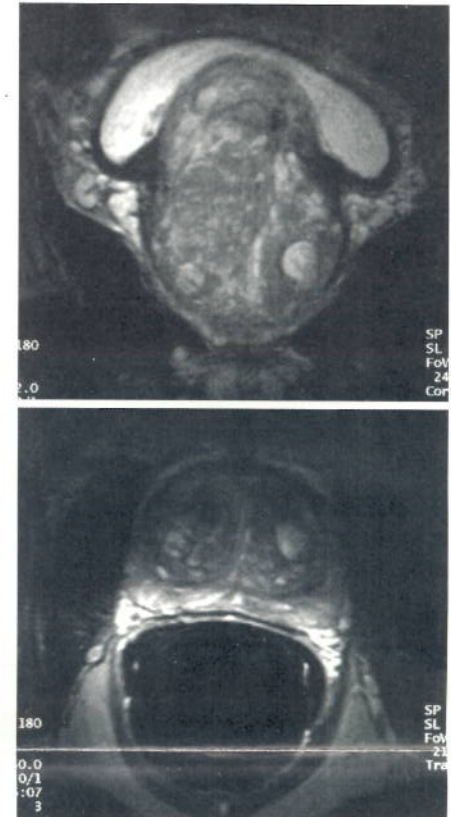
A. Coronal and B. axial Turbo Spin Echo T2-weighted (TR 7102, TE 112) endorectal coil images of patient with BPH. The brighter peripheral zone is compressed by BPH in the central portion of the gland.
